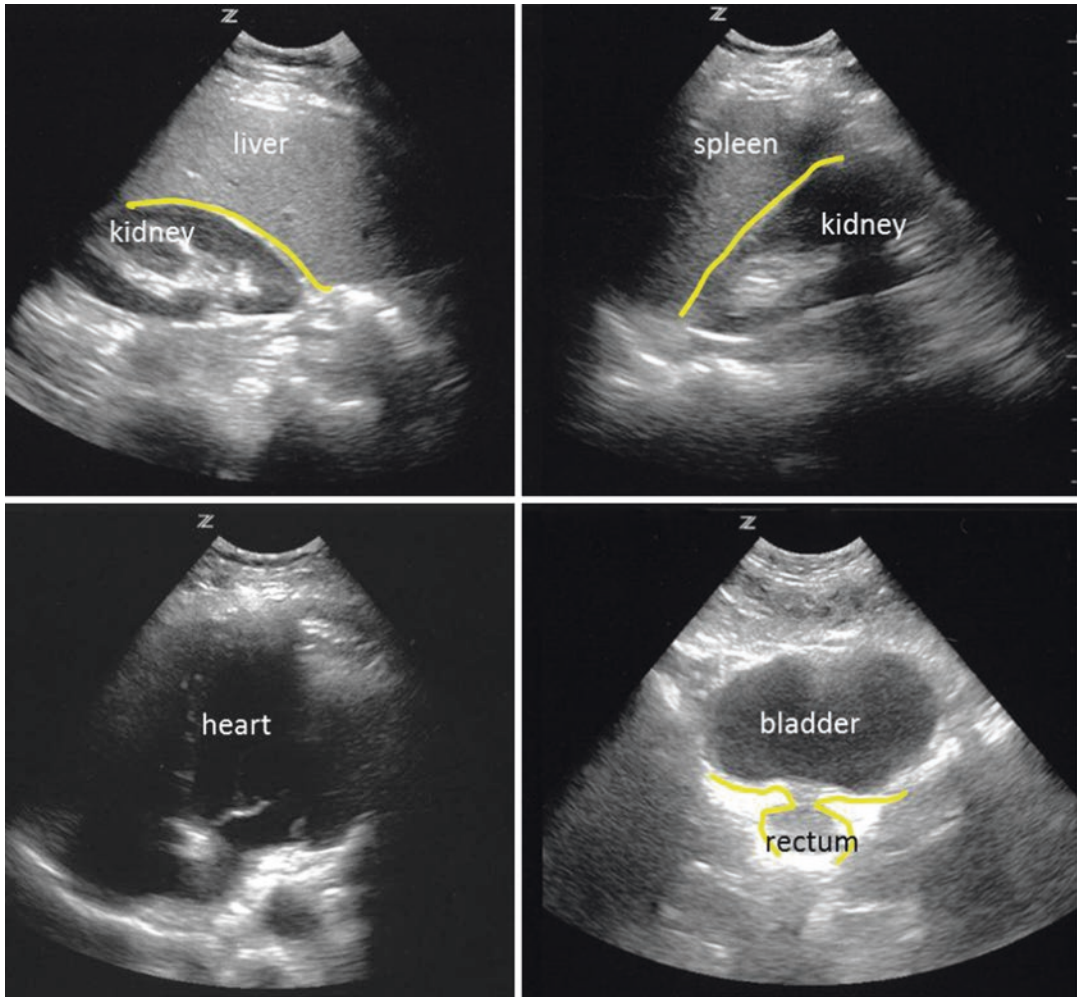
Representative images from FAST (focused assessment with sonography for trauma); *yellow lines* mark perihepatic (u.l.) and perisplenic space (u.r.) and rectouterine pouch (d.r.)
